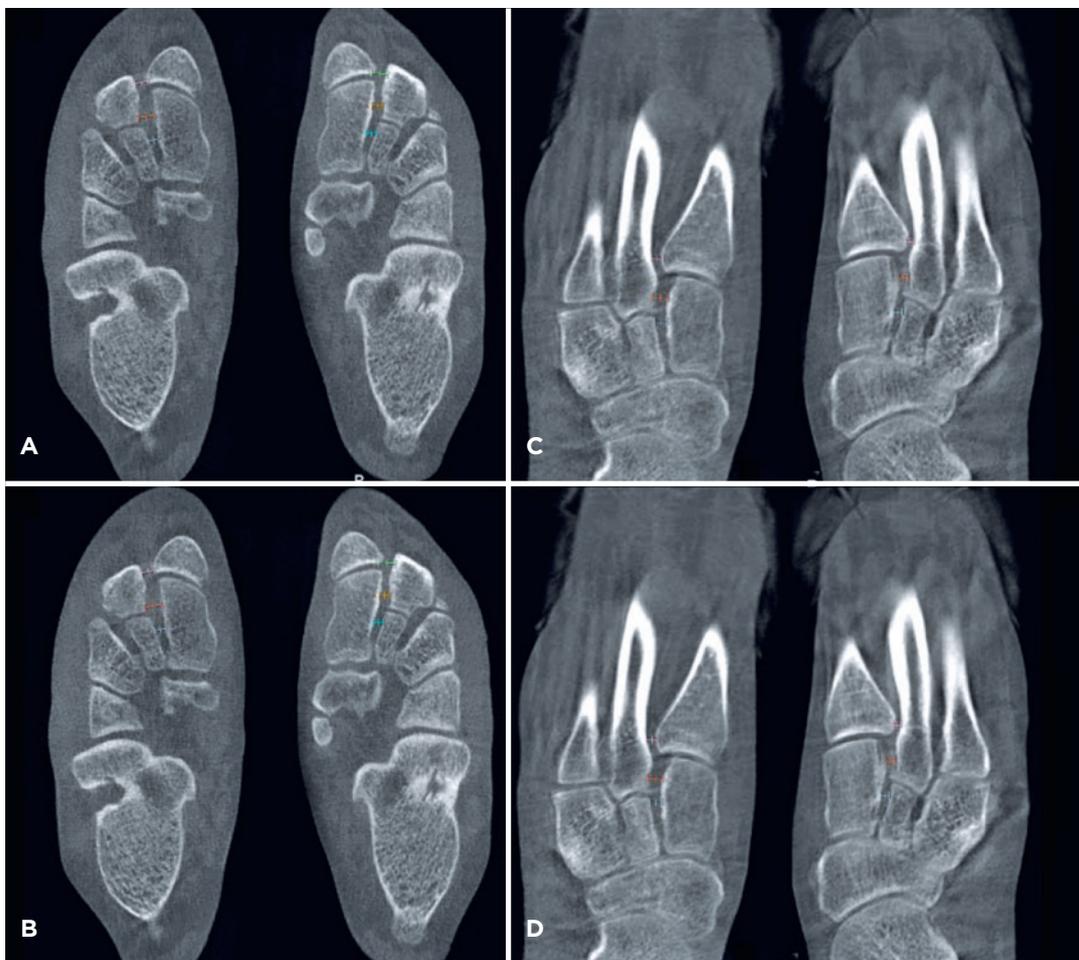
Weight-bearing computed tomography of a female patient with Lisfranc injury on the right foot. Axial plane of the feet. A) Sitting; B) Regular weight-bearing; C) Demi-pointe weight-bearing; and D) Pointe weight-bearing.
